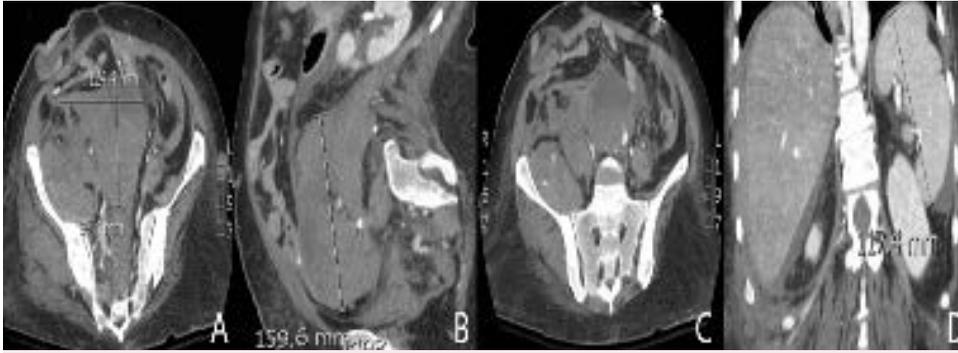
Abdominopelvic computed tomography scan showing large retroperitoneal hematoma measuring approximately 9.5 x 12.4 cm in maximum axial dimension (A) and spanning at least 16.0 cm in maximum craniocaudal dimension (B). Small blush of contrast within the hematoma is present near the bifurcation of the left common iliac artery with extension of the retroperitoneal bleeding to the right iliacus (C). Perisplenic and perihepatic hemorrhages are present (D).
